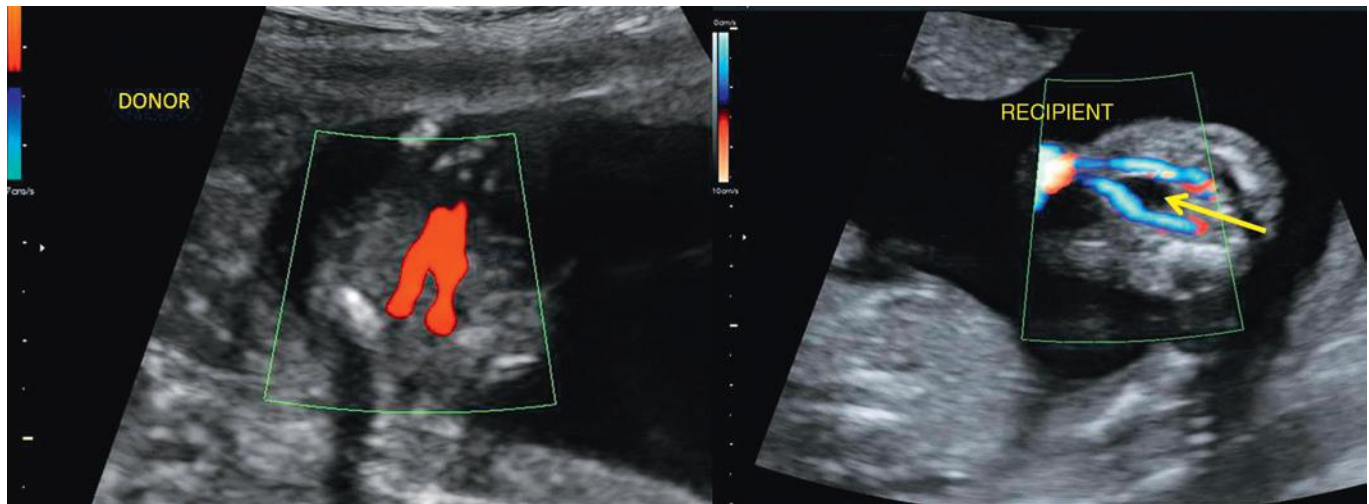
Twin-twin transfusion syndrome, stage II. Monochorionic diamniotic twin pregnancy with oligohydramnios and polyhydramnios (not shown). Nonvisualization of the empty bladder in the donor. Fluid shown within the normal-appearing bladder (*arrow*) of the recipient. Color Doppler demonstrates flow within the umbilical arteries, which flank the bladder, of each twin.
